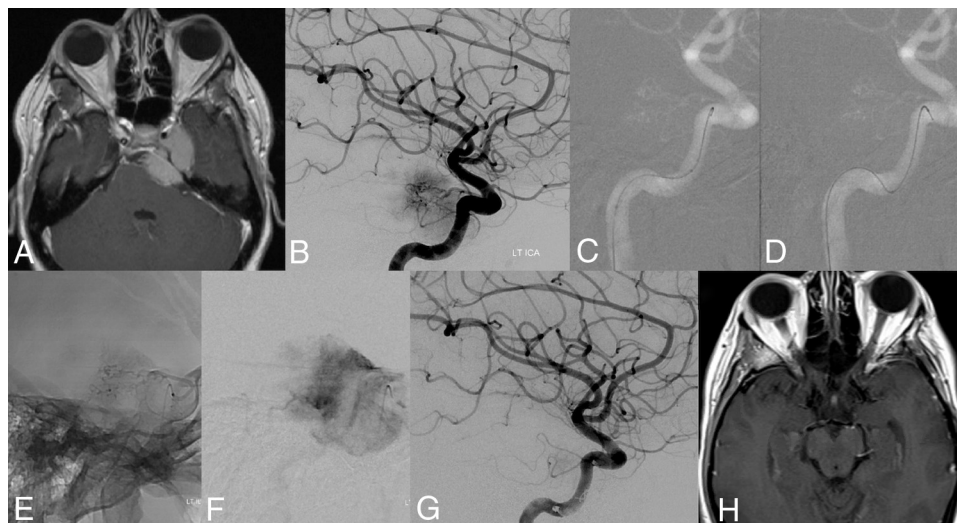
A patient with a Meckel cave meningioma also with involvement of the cavernous sinus visible on a T1-weighted, axial, postcontrast image (A). Right ICA DSA injection in lateral view (B) demonstrates the supply to the tumor from an enlarged inferolateral trunk from the left ICA. Inferolateral trunk catheterization is performed with a Headway Duo over a Synchro-14 microguidewire (C and D). MICRO DSA performed through a microcatheter on a lateral view (unsubtracted, E, and subtracted, F) better demonstrates the selective supply to the meningioma. Final lateral view ICA injection (G) demonstrates marked interval reduction of blush in the region of the tumor. Complete gross resection of the meningioma is visible on a T1-weighted, axial, postcontrast image (H). LT indicates left.
